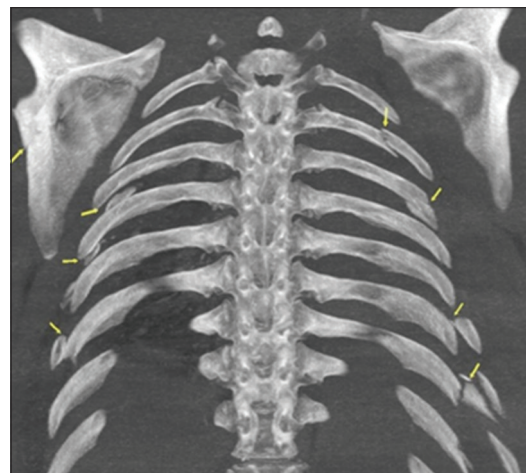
Non-contrast computed tomography chest with reconstructed MIP image demonstrate multiple bilateral ribs fracture (yellow arrows) in a patient following road traffic accident
